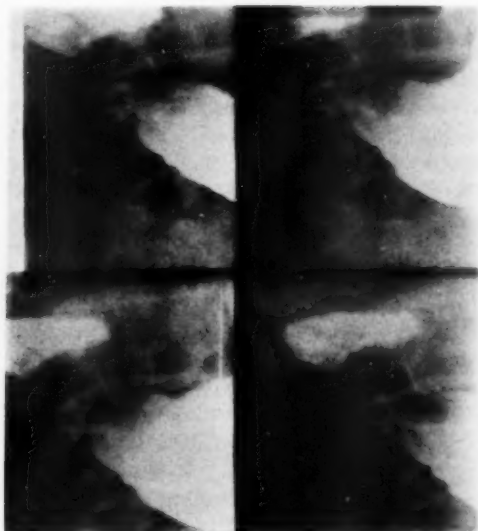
Case IX. Female aged 59. X-ray diagnostic problem.
